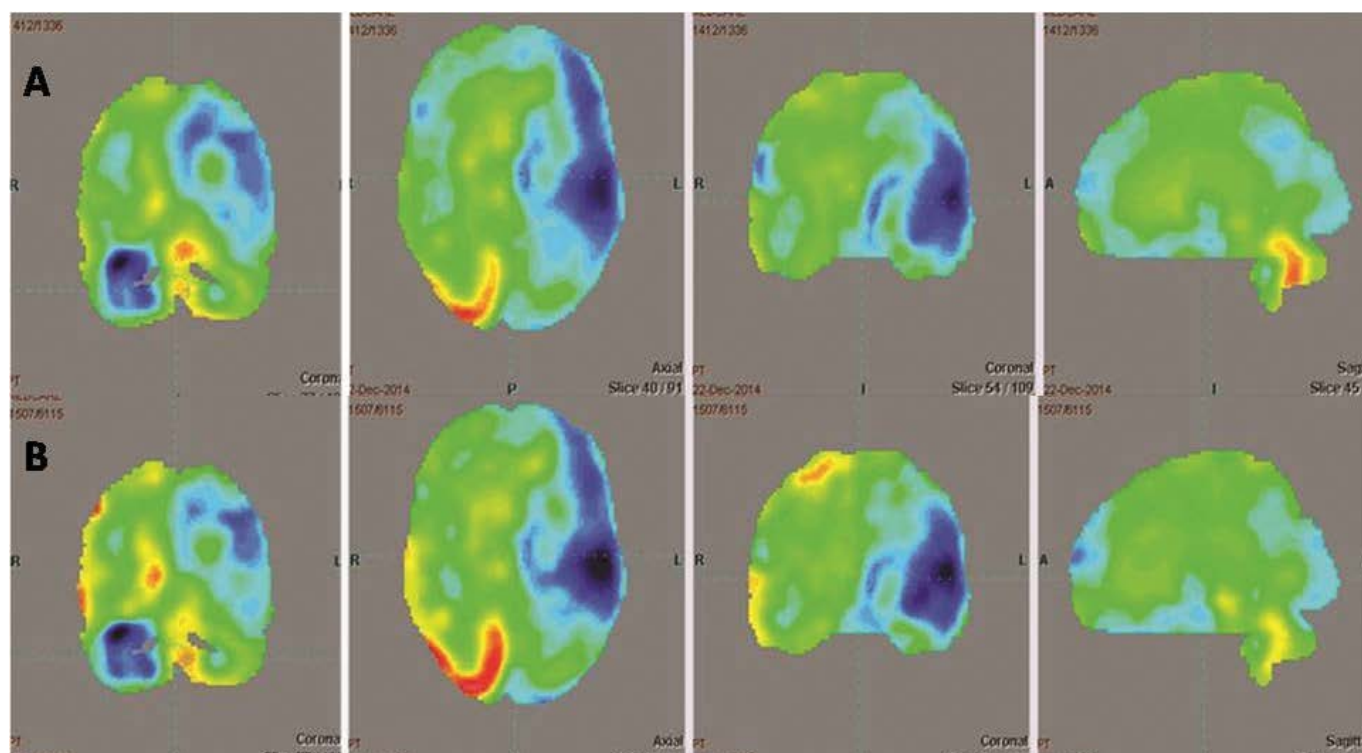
(A). Pre-intervention, PET-CT scan brain showing areas of hypometabolism (blue and black areas) in the left cerebral hemisphere. (B) Change in the PET-CT scan brain imaging over 6 months showing areas of improved FDG uptake (reduced blue and black areas) in fronto-parietal areas of left cerebral hemisphere.
